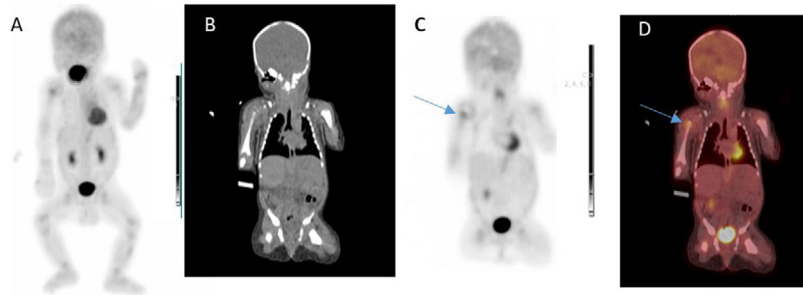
(A) Maximum intensity projection image. (B) Coronal CT image. (C) Coronal PET image. (D) Coronal PET/CT fusion image: ^{18}F -FDG imaging with high uptake in the proximal epiphysis of the right humerus (blue arrow) associated with active osteomyelitis² and moderate uptake in the articular surface of the right humeral head associated with the already established active articular illness.
